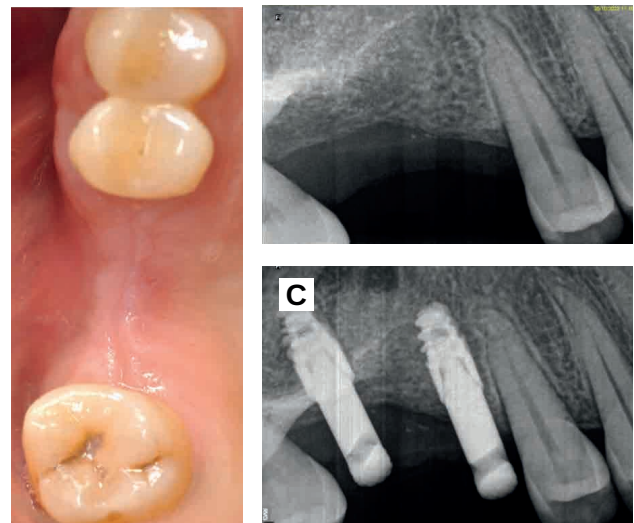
A. Postoperative appearance at 6 months. B. Preoperative periapical radiograph prior to implant placement. C. Placement of the implants.
